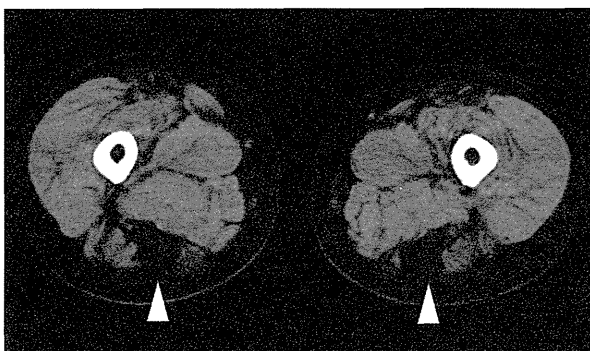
Muscle image. Representative image showing preferential involvement of semitendinosus muscles. CT images of skeletal muscles in proximal legs of the patient K. Δ : semitendinosus muscles.
